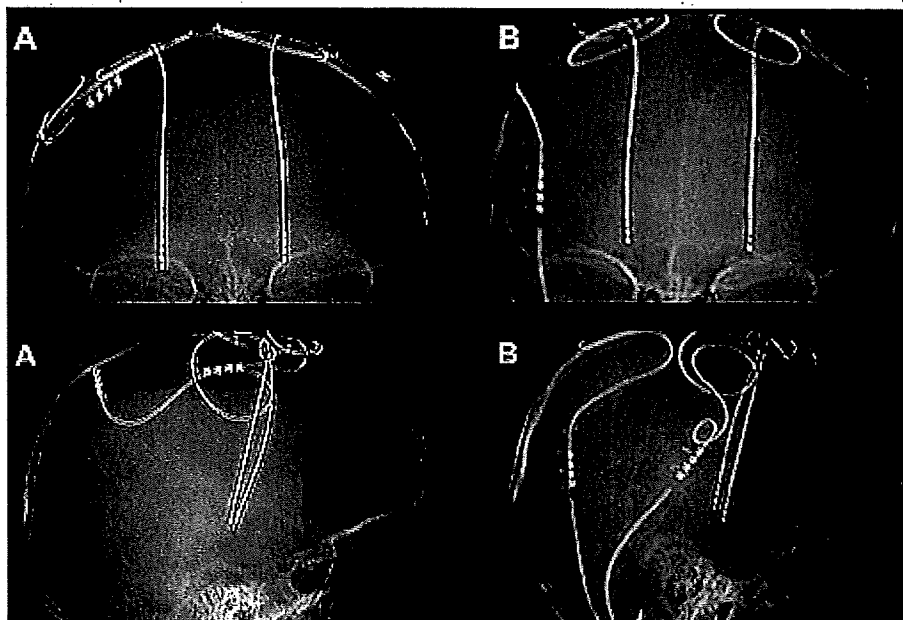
A skull x-ray revealed an extension cable fracture.
